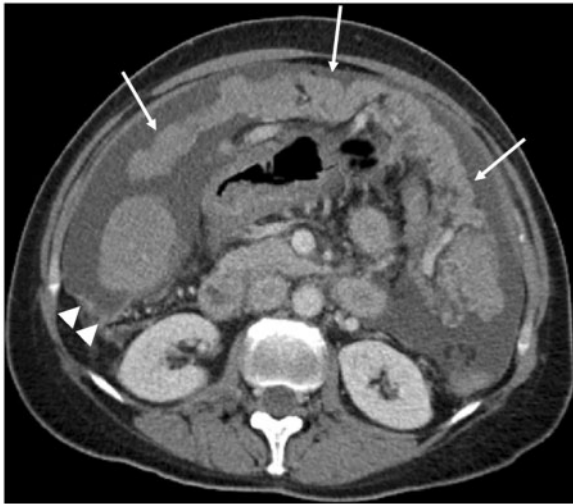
Greater omentum deposit. Axial contrast-enhanced CT shows extensive tumour involvement of the greater omentum (arrows), giving rise to an omental cake secondary to ovarian carcinoma. Note associated ascites and nodularity of the right paracolic peritoneal reflection (arrow heads).
